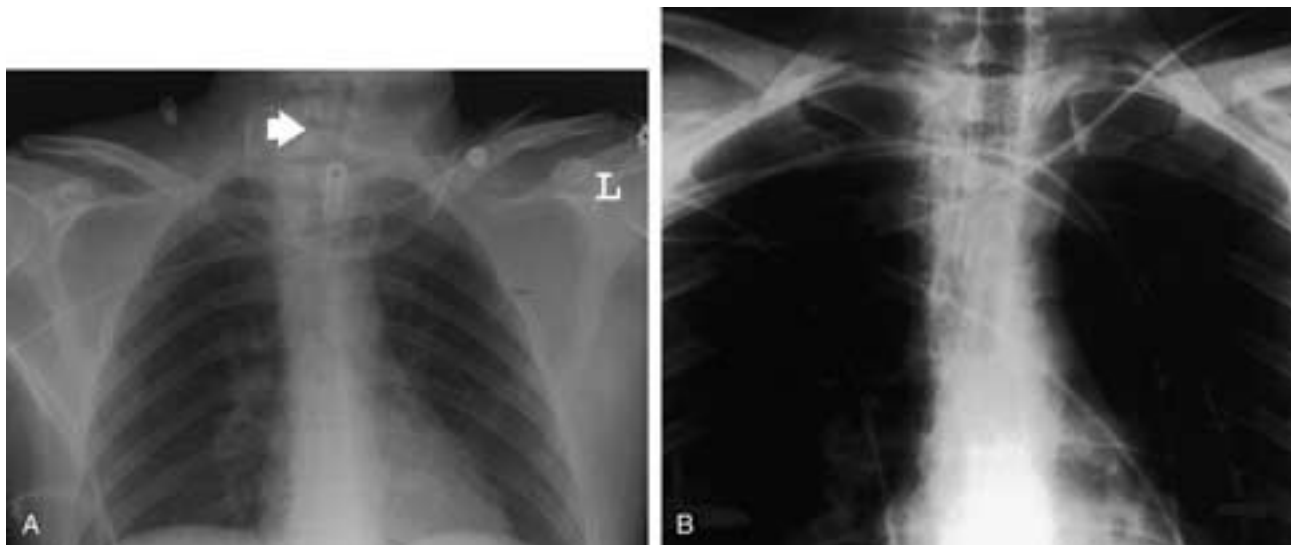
Tracheal stent. A 30-year-old male who suffered from an accidental pistol discharge was intubated for 20 days. Approximately 1 week following extubation, he developed difficulty breathing and was found to have granulation tissue causing tracheal stenosis. A covered tracheal stent was placed, providing relief of symptoms. A, Pre-stent AP chest X-ray shows narrowing of the subglottic airway above the level of the tracheostomy (arrow). B, Anteroposterior view of the chest following stent placement demonstrates the covered tracheal stent extending from the subglottic trachea to approximately 3 mm above the carina.
